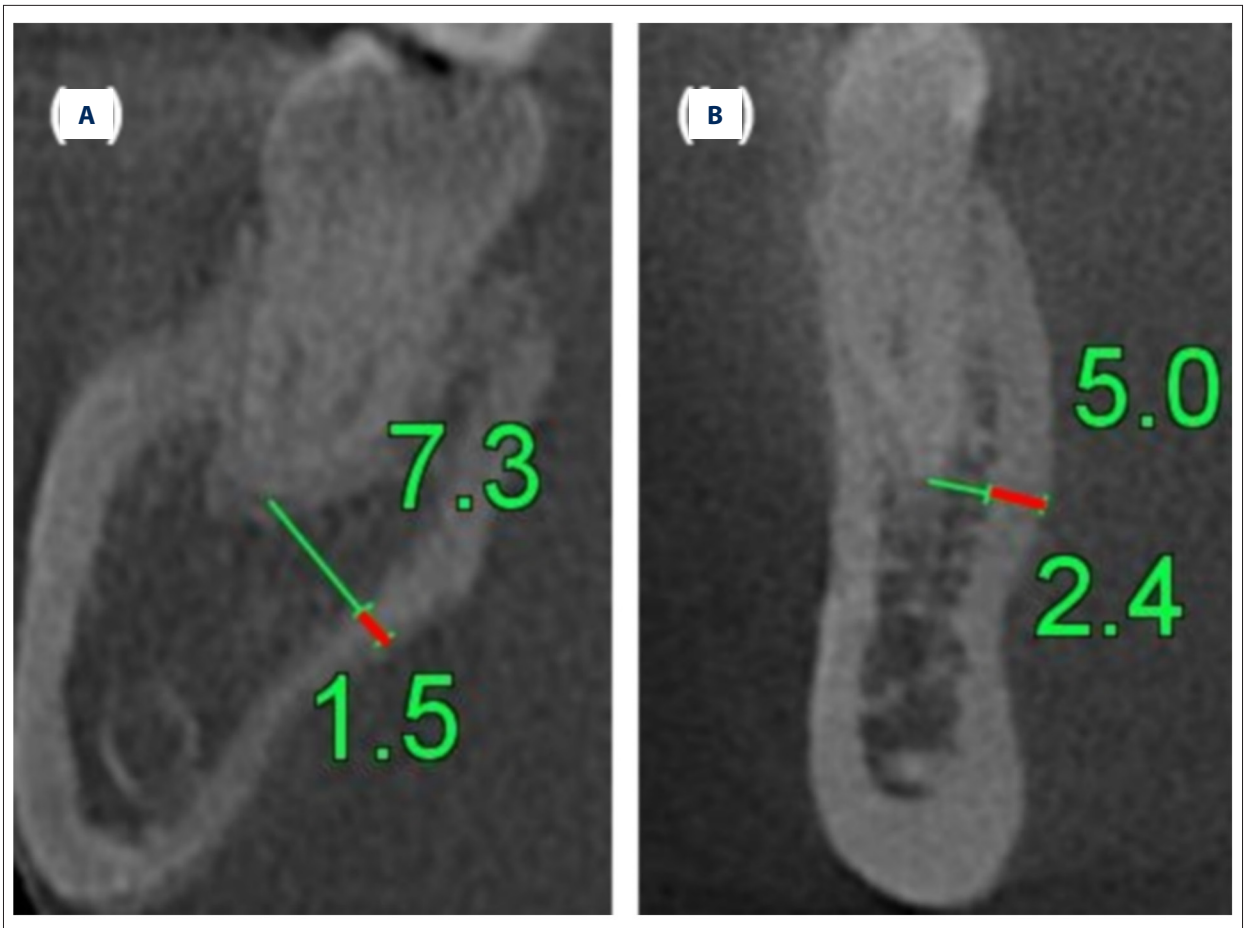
Examples of CBCT measurements of closest distances from the root apex to the lingual cortical plate and the thickness of lingual plate at the level of first measurement. (A) Exemplary measurements for mandibular second molar tooth and (B) Exemplary measurements for mandibular second premolar tooth.
